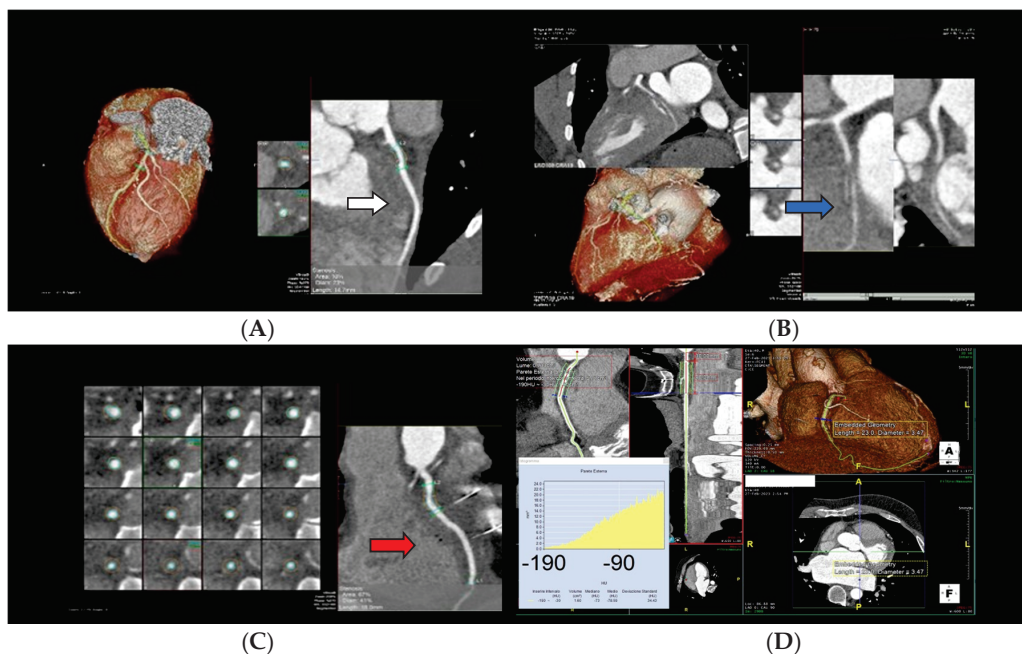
Evaluation of cardiac plaques in OTC (orthotopic cardiac transplantation) patients by CCT (cardiac computed tomography). The squares represent details of the extent of coronary stenosis. (A) Mild LAD (left anterior descending artery) circumferential soft plaque (white arrow); (B) Occlusion of LCx (left circumflex) artery (blue arrow); (C) Mild RCA (right coronary artery soft plaque (red arrow); (D) Increased pericoronary fat attenuation index values suggestive of coronary artery inflammation. Pictures from our archive.
